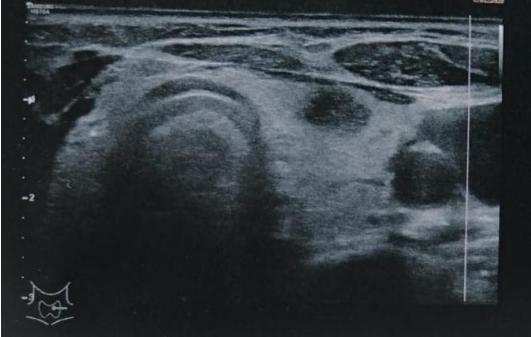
B-mode ultrasonography showing thyroid hypoechoic nodule of the left lobe
